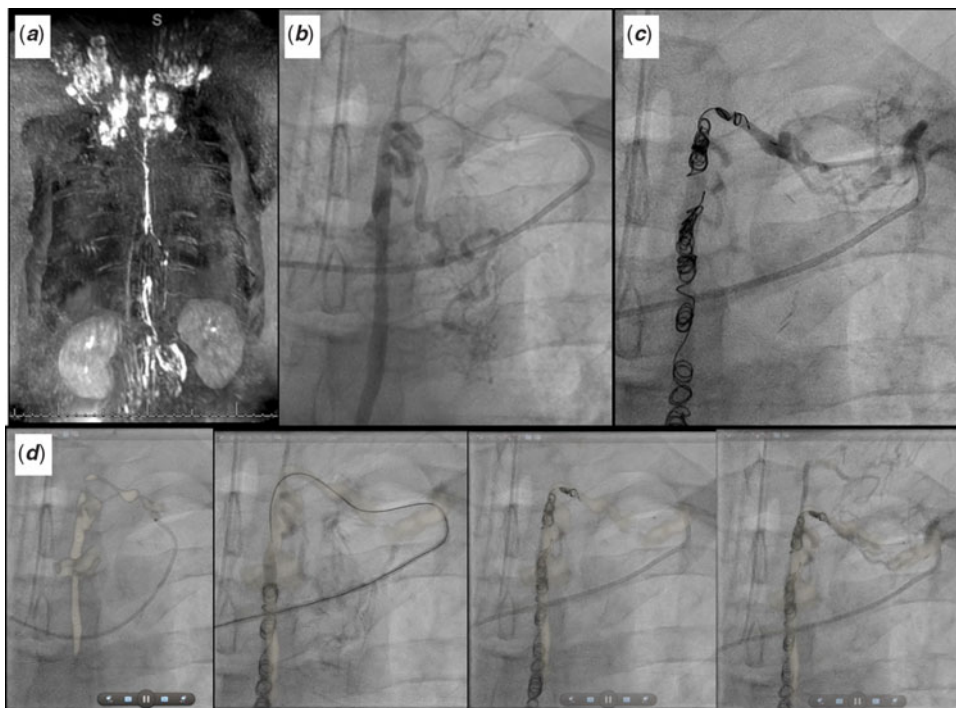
Fontan patient with plastic bronchitis undergoing thoracic duct lymphatic embolisation with overlay guidance. (a) Dynamic contrast magnetic resonance lymphangiogram showing significant lymphatic insufficiency with a dilated, intact lymphatic duct draining to the left innominate vein. (b) X-ray fluoroscopic lymphangiogram. (c) Post-coil occlusion X-ray fluoroscopic lymphangiogram. (d) Series depicting thoracic duct lymphatic embolisation with overlay guidance.
